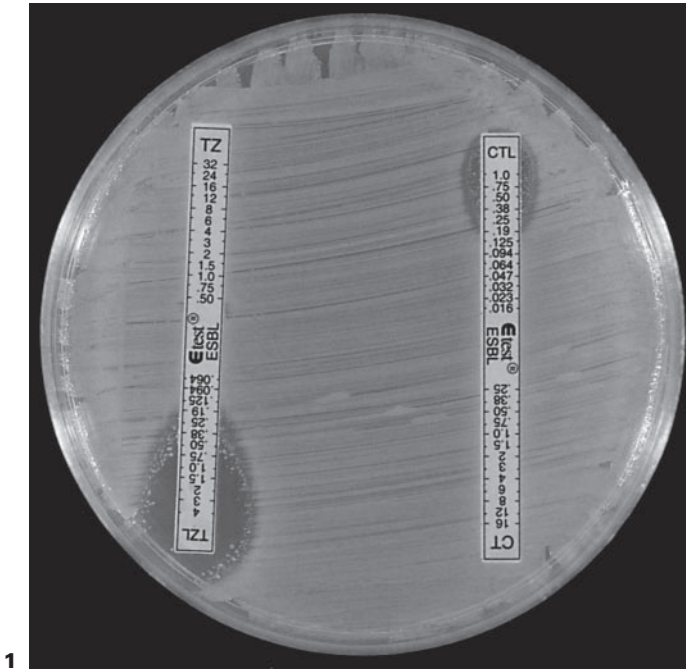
A clear-cut E test ESBL positivity in *E. coli* showing MIC of CT/CTL = 16/0.23, ratio >8 and MIC of TZ/TZL = 32/0.19, ratio >8. CT = Cefotaxime; CTL = cefotaxime combined with clavulanic acid; TZ = ceftazidime; TZL = ceftazidime combined with clavulanic acid.
